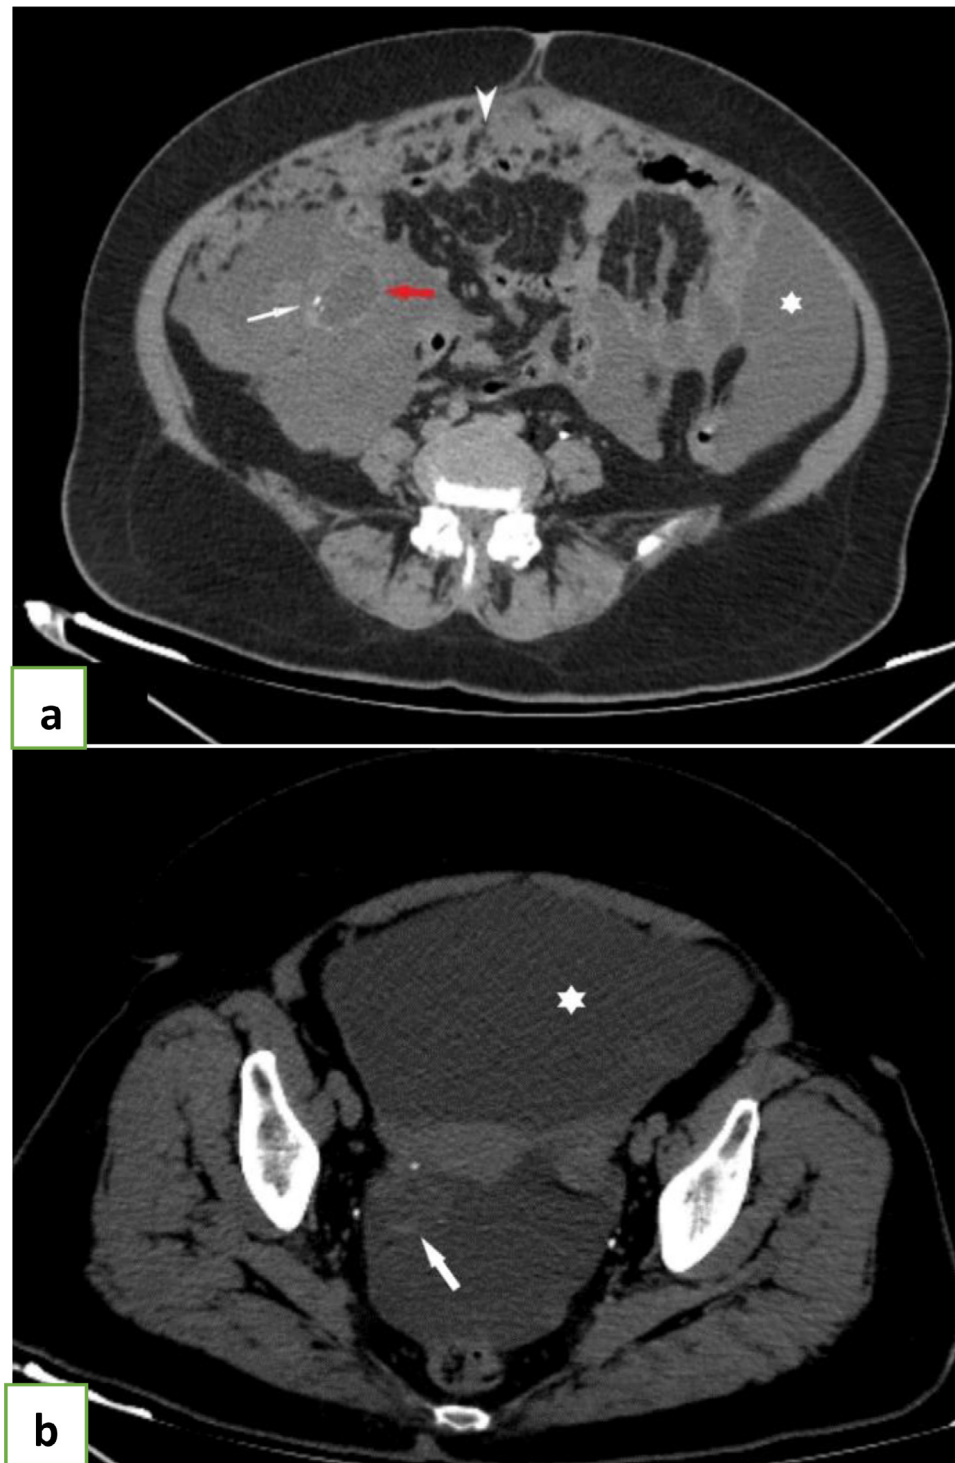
Abdominal post injection CT scan showing a cystic mass in the right lower quadrant, in contact with the caecum (red arrow) containing mural calcifications (with arrow) (A) and pelvic cystic mass (B) (large white arrow), CT also showed nodular and thickening of peritoneal reflections with stranding and thickening of the omentum (head arrow) and peritoneal effusion (Asterisk). (Color version of figure is available online.)
